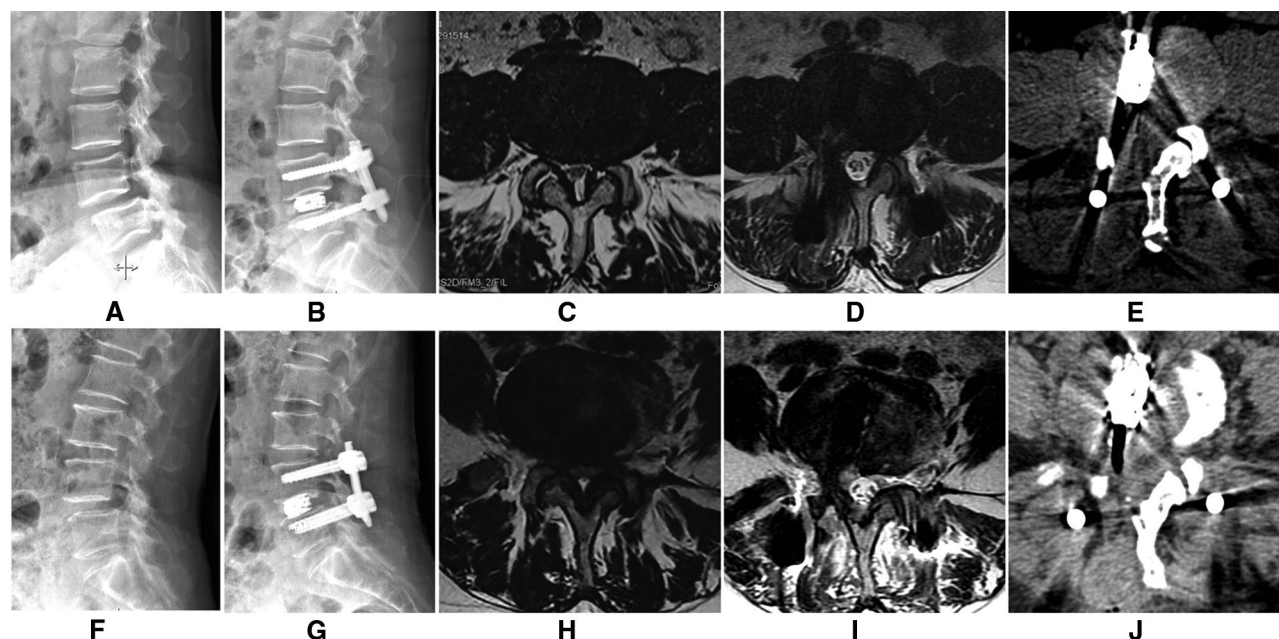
The lateral X-Ray showing L4 spondylolisthesis (A), and it was complete reduction after surgery (B). A cross-sectional MRI image (C) showing lumbar spinal stenosis; the cross-sectional area of the spinal canal significantly improved after surgery (D). A cross-sectional CT image (E) showing that a part of the lamina, the articular process, and the base of the spinous process are excised to enlarge the spinal canal. The other patient is shown in (F–J).
